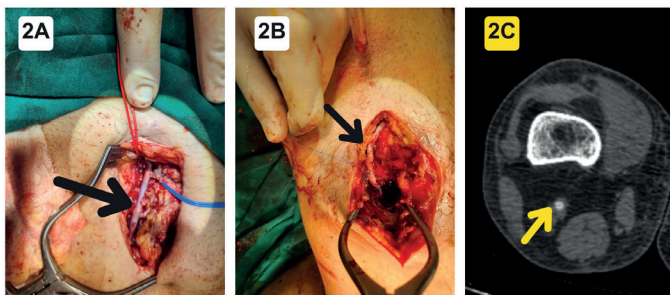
A, B. Femoropopliteal bypass with greater saphenous vein, C. Control CT image in postoperative 14th day
